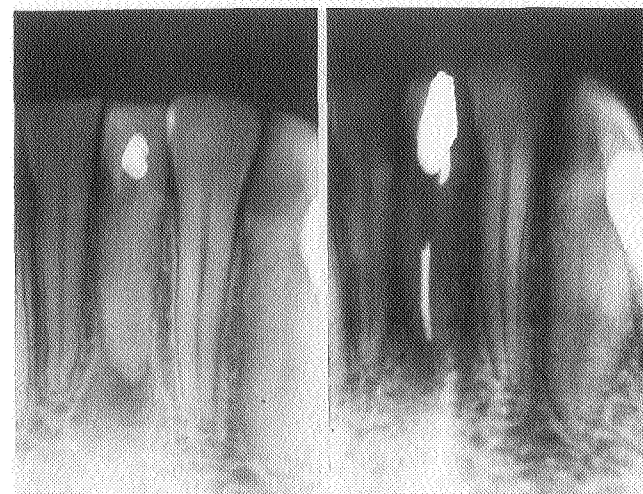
(a) Apparently obliterated pulp canal, seen on radiograph (b) Canal can still be found
